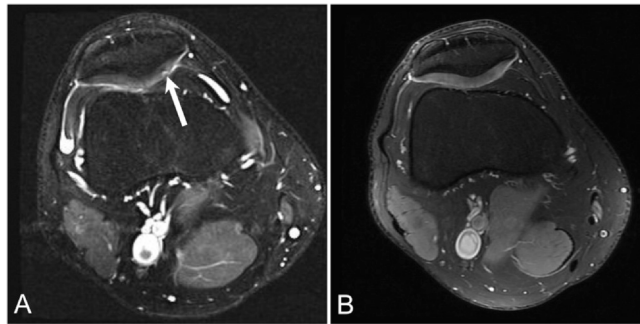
Elite basketball center imaged following an injury during a game. Axial T2 FS MR image (A) of the knee demonstrates focal low-grade cartilage fissuring/fraying at the medial patellar facet (arrow). This was an incidental finding unrelated to the acute injury but new compared to the axial PD FS MR image (B) from an MRI obtained 2 years prior. This case also highlights the difference in the appearance of articular cartilage on T2 and PD sequences with fat suppression. Note that the internal cartilage composition is better evaluated on the PD sequence due to the higher spatial resolution and intermediate weighting. FS, fat saturation; MR, magnetic resonance; MRI, magnetic resonance imaging; PD, proton density.
